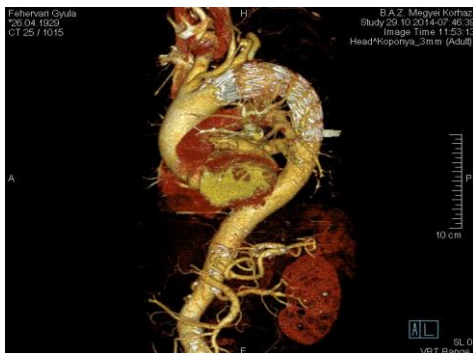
Angio-CT with 3D reconstruction
